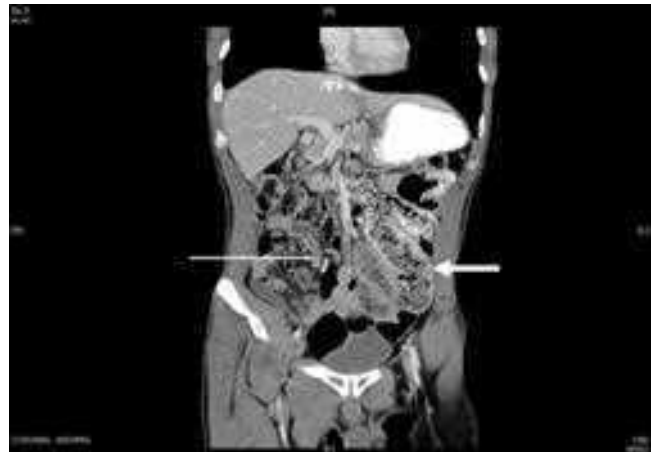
Chronic partial small bowel obstruction. This patient presented with a several-month history of chronic abdominal pain and intermittent vomiting. The coronal computed tomography image shows grossly dilated loops of proximal small bowel on the left side (*wide arrow*), with decompressed loops of small bowel on the right side (*narrow arrow*). The dilated segment shows evidence of feculization of bowel contents, consistent with the chronic nature of the obstruction. Patient's vomitus had characteristic feculent smell and quality. At exploratory laparotomy, adhesive band were identified and divided.
